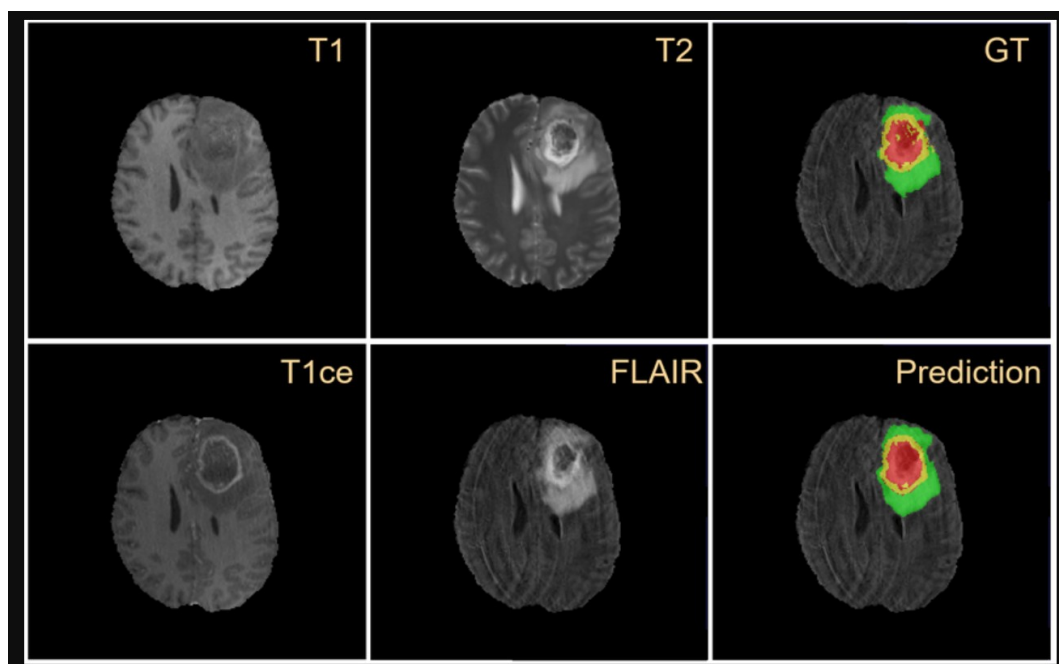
Multiple MRI modalities—such as T1, T2, T1ce, and FLAIR
